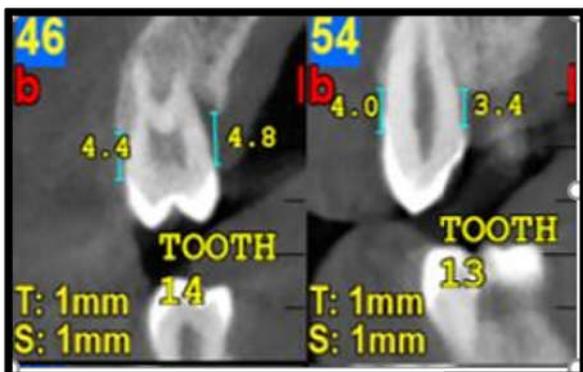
PRE-OP CBCT IBD Measurements
